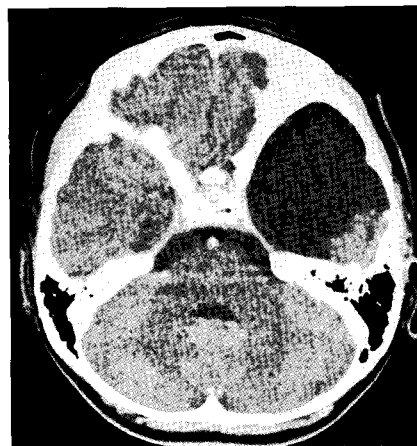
Contrast enhanced axial CT scan demonstrating a hypodense arachnoid cyst in the left temporal region.
